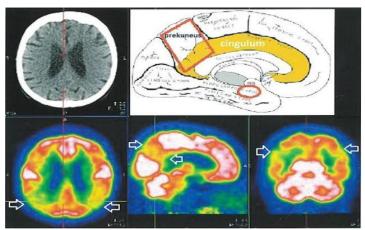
¹⁸FDG PET/CT in patients with Alzheimer's disease; on transverse (bottom left) and coronal plane (bottom right) weakened FDG accumulation is detected in the cortex of lateral parts of the parietal lobes, and on sagittal plane through the mesial cortex of the right parietal lobe (bottom center) weakened FDG accumulation in the precuneus and posterior cingulate cortex. From the book Nuclear Medicine, Faculty of Medicine, Belgrade 2020.
